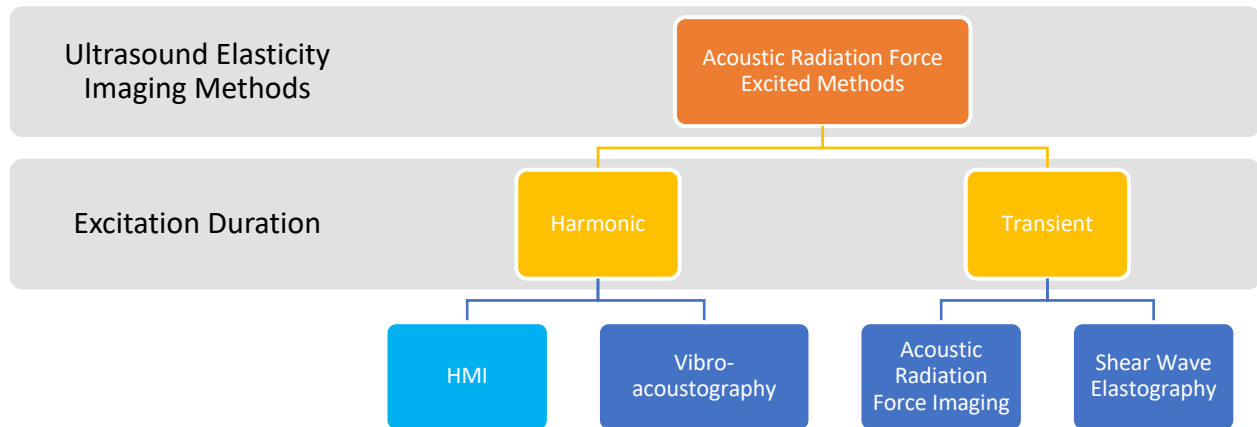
Ultrasound-based elasticity imaging methods can be categorized by the excitation source used to deform soft tissue. As presented herein, acoustic radiation force-based elasticity imaging methods can be further classified according to the duration of the applied acoustic radiation force excitation.
